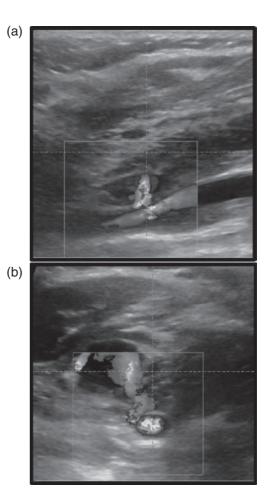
Duplex ultrasound revealing an arteriovenous fistula between the internal jugular vein and the common carotid artery after venous access. a) Sagittal view b) Transverse view.
